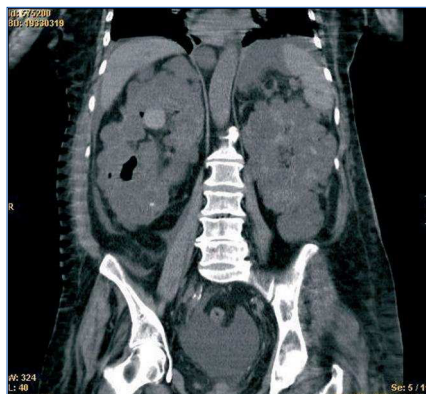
Abdominal CT scan: coronal with complicated cyst in upper third right kidney and air in the urinary tract.
